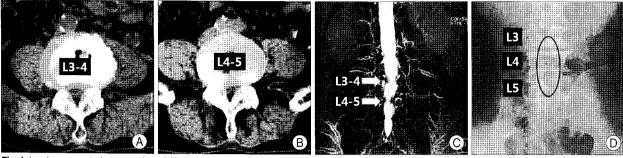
Lumbar computed tomography axial images at L3-4 (A), L4-5 (B) reveal narrowed spinal canal. Lumbar magnetic resonance myelography shows dural sac indentations at L3-4, L4-5 (C). Postoperative lumbar spine X-ray AP view shows laminectomy defect at L3-5 (in black circle) (D).
